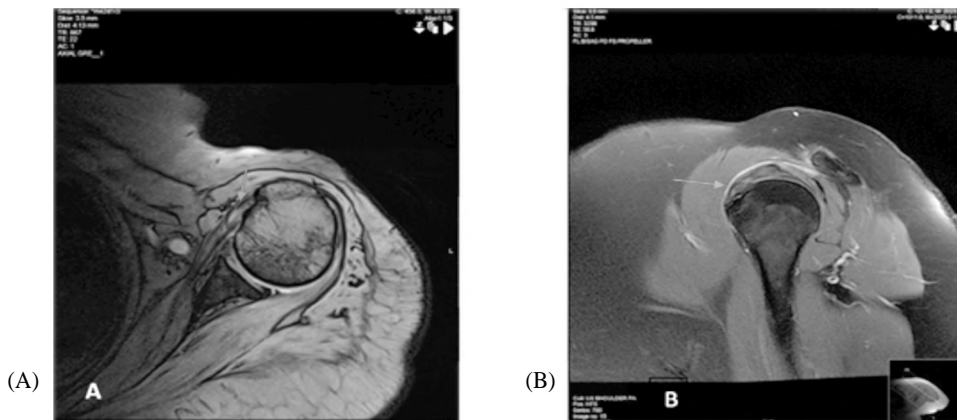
MRI axial GR WI (A) and sagittal PD fat suppression (B) Showing abnormal intermediate signal of the subscapularis tendon with relative increase of its girth (red arrows) denoting tendinopathy.
